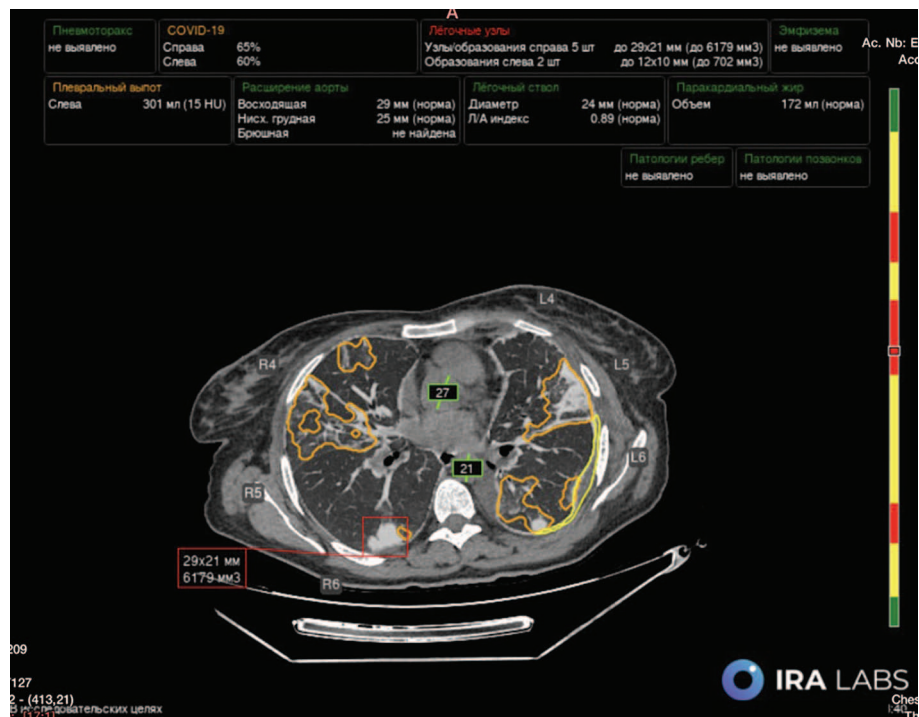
Processing of chest computed tomography images using multi-target artificial intelligence technology.
